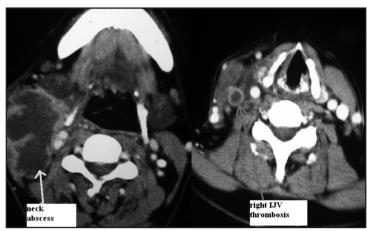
CT scan of this patient demonstrating huge neck abscess with right IJV thrombosis.
